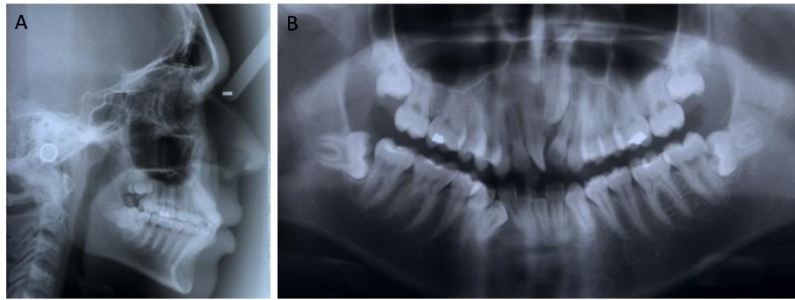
Initial lateral and panoramic radiographs.
